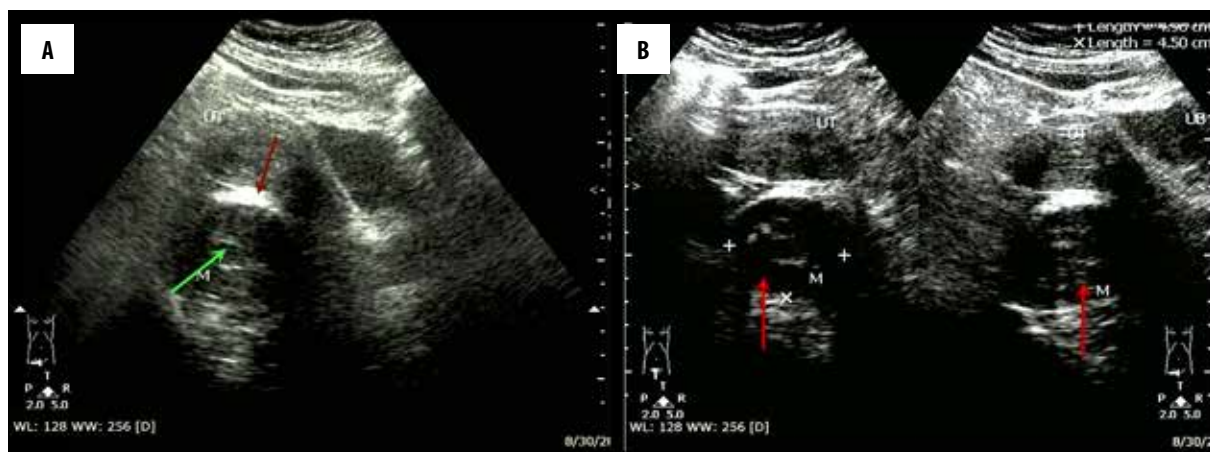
(A) Ultrasound examination of the pelvic region reveals a homogeneously hypoechoic solid mass in the presacral region, which compresses the rectum (echogenic rectal air denoted by red arrow) and showing foci of nodular calcifications (green arrow). (B) Ultrasound examination of the pelvic region reveals a homogeneously hypoechoic solid mass in the presacral region (red arrows), which measures 4.6×4.9 cm in size (measurements shown in the upper right corner).
